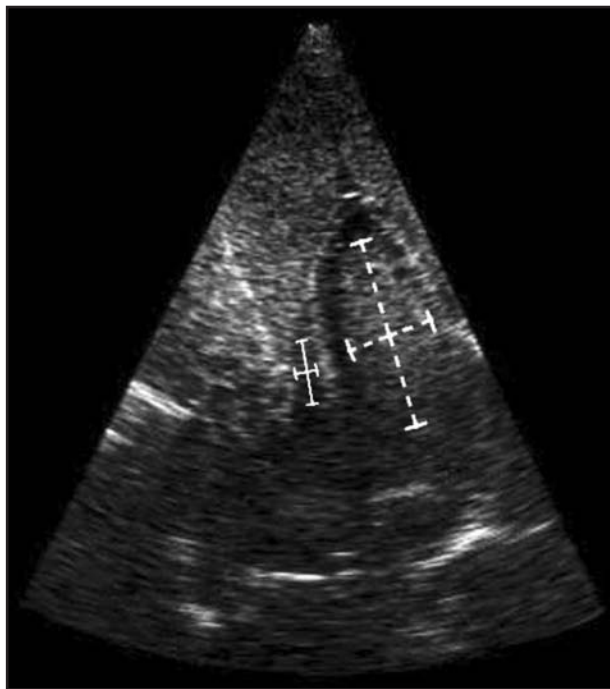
Contrast transcoelomic echocardiographic horizontal view of the heart of a red-tailed hawk in diastole, as obtained through a ventromedian approach to transducer probe placement (frame rate, 225 Hz; depth, 4 cm). See Figure 1 for remainder of key.
